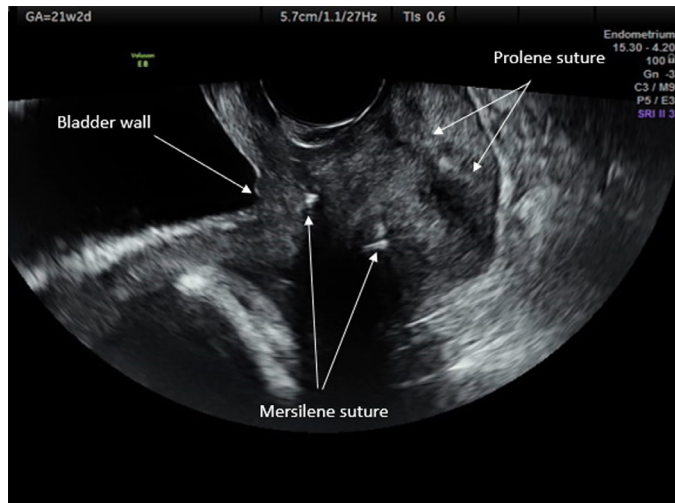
Transabdominal ultrasound image of a patient following emergency cervical cerclage
